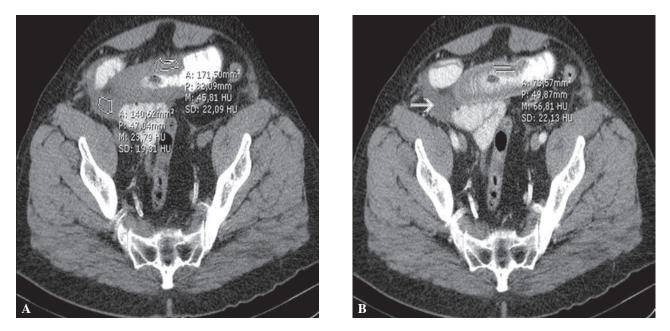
A 35 year-old male who used an oral anticoagulant after placement of a prosthetic valve (patient #3 of Table 1) (A) Axial pre- and (B) post-contrast CT images show a thickened ileal wall (pre-contrast value ; +45 HU, post-contrast value ; +66 HU). The white arrow shows a hemoperitoneum.
